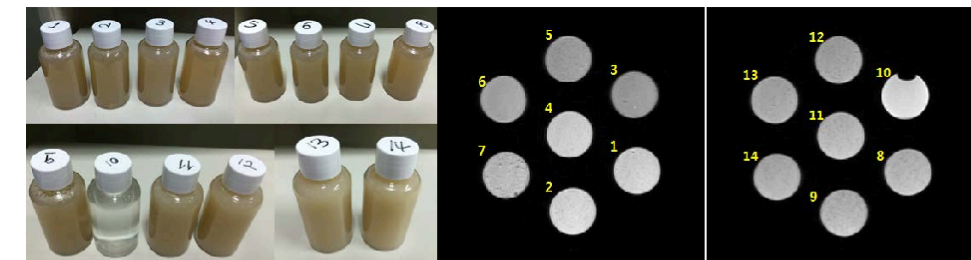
14 different developed tissue-equivalent materials (Left) and its MR image for each plug listed in Table 1 with TR 15,000 ms, TE 15 ms. (1 White matter, 2 Gray matter 3 Muscle, 4 Liver-1, 5 Liver-2, 6 Kidney, 7 Heart, 8 Prostate, 9 Spinal cord, 10, Water 11 Bone marrow, 12 Pancreas, 13-14 Breast fat. Air plug listed in Table 1 was not shown in this figure. Number 14 plug was replaced with Air plug in final experiment.)
